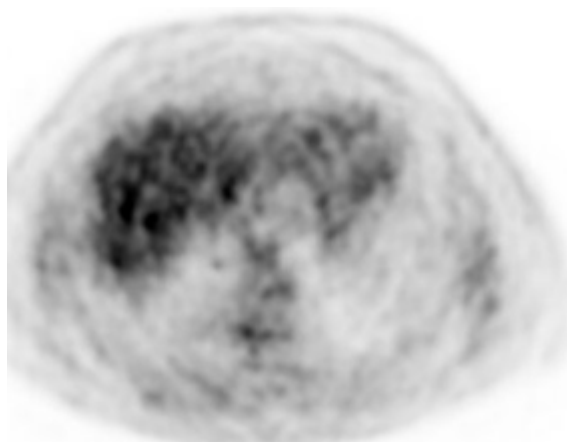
Negative PET/CT Scan at the Same Level.
